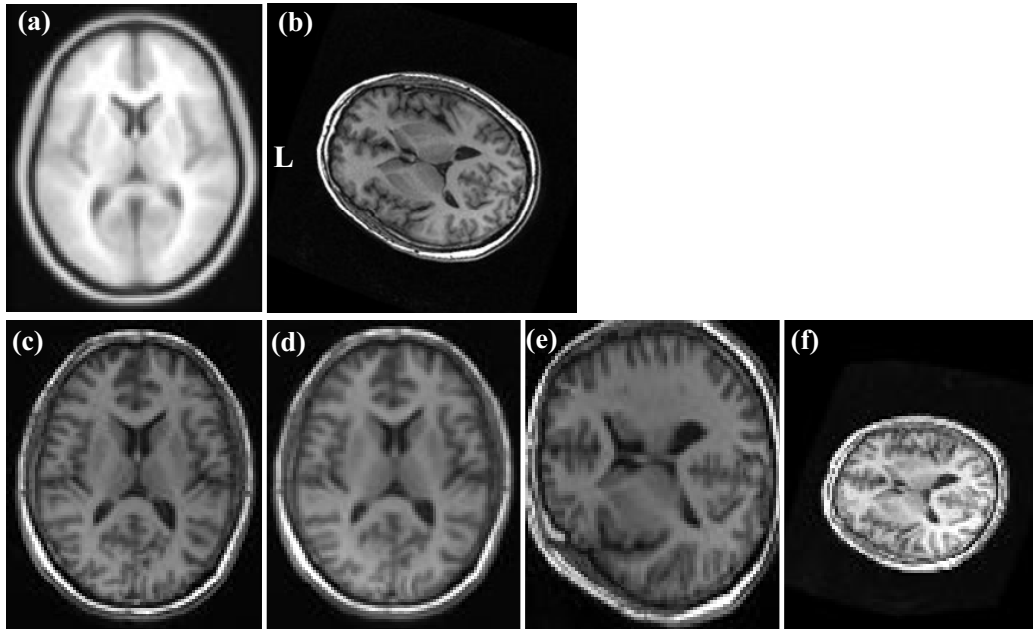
The affine registration for brains with large orientation difference. (a) The ICBM-152 brain template used as the target image. (b) A T1-weighted image used as the source image. The affine-registered result using (c) BIRT, (d) FLIRT, (e) SPM2, and (f) AIR5.
